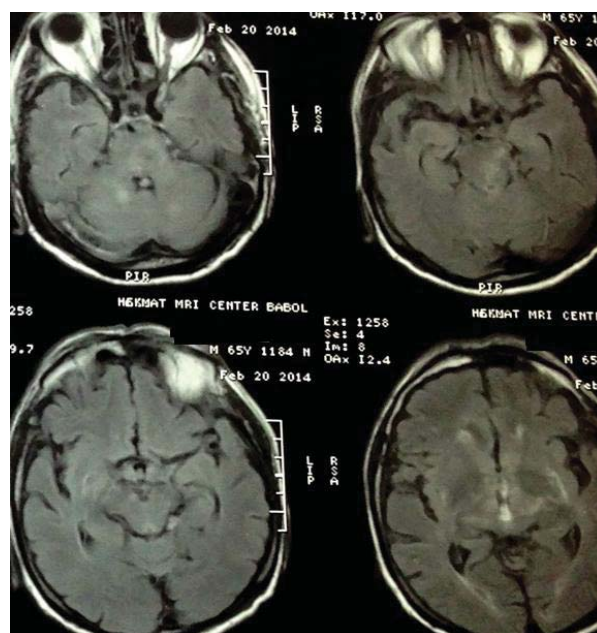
Magnetic Resonance Imaging revealed improvement of lesions after treatment
